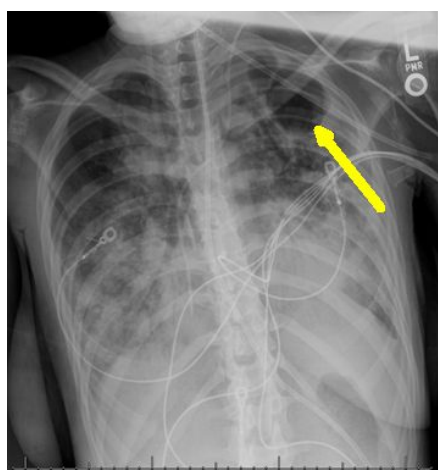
Chest x-ray depicted the left upper lobe cavity (yellow arrow).
